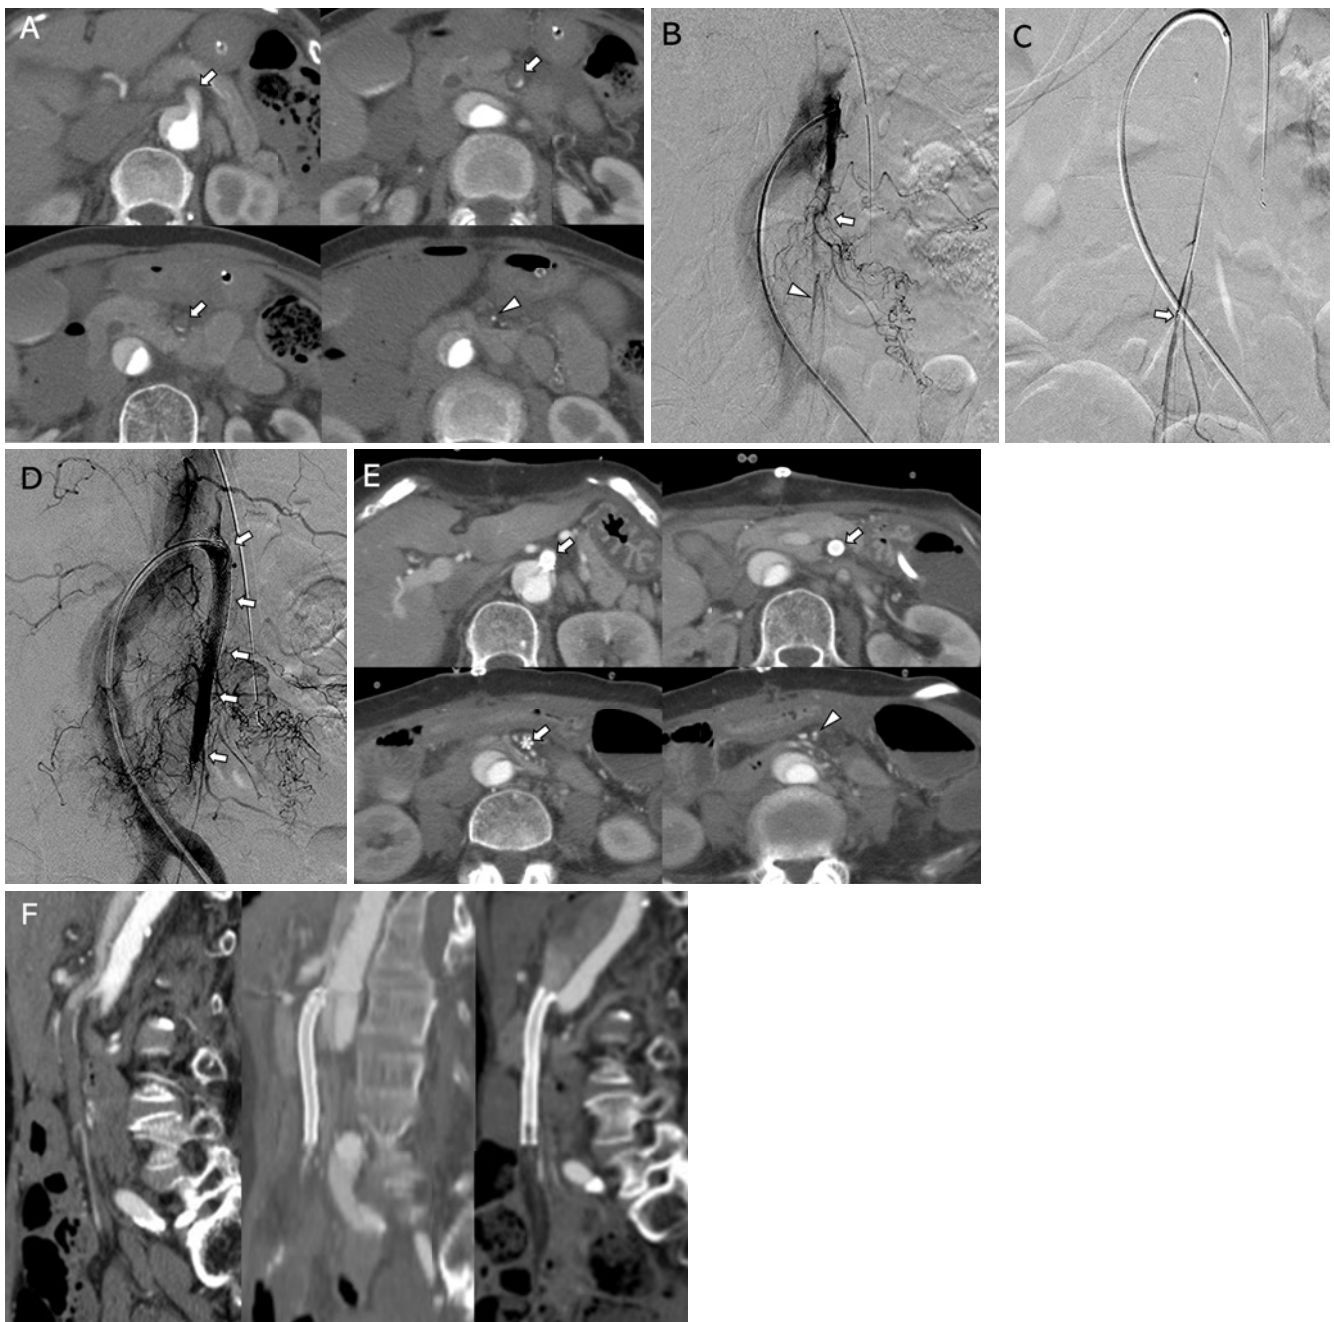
Images of a woman with Stanford type A aortic dissection complicating superior mesenteric artery (SMA) malperfusion (case 10). (A) Contrast-enhanced computed tomography (CECT) after ascending aortic replacement shows obstruction of the true lumen of the SMA by the thrombosed false lumen (arrow). The diameter of the SMA distal to the dissection (arrowhead) was 3.0 mm. (B) True lumen angiography of the SMA demonstrated obstruction of the SMA (arrow). The SMA distal to the ileocolic artery (arrowhead) was perfused by collaterals. (C) A 6 F guiding sheath (Ansel Guiding Sheath, Cook Medical, Bloomington, IN, US) was placed in the SMA orifice, and a 1.8 F microcatheter (Carnelian PIXIE, Tokai Medical Products, Aichi, Japan) was advanced distally to the dissected SMA through the true lumen. Next, angiography demonstrated the tip of the microcatheter (arrow) was in the true lumen of the SMA beyond the dissected lesion. (D) After exchanging a guidewire for a hard guidewire (Amplatz Super Stiff Guidewire, Boston Scientific, Marlborough, MA, US), a 7 mm diameter self-expanding stent (SMART Control, Cordis, Bridgewater, NJ, US) was placed in the SMA. Angiography after stent (arrow) placement showed improved flow of the side branches of the SMA; however, the SMA at the distal portion of the stent was poorly contrasted, and the in-stent flow was slow. Resection of the distal ileum and right hemicolon was performed immediately after stenting. (E) CECT 8 days after stenting showed that the stent (arrow) and SMA distal to the stent (arrowhead) were patent. (F) CECT curved planar reconstruction images before (left), 8 days (center), and 3 years (right) after stenting. CECT 3 years later shows that the proximal end of the stent is located in the false lumen of the aorta due to an intimal flap tear within the aorta by the proximal edge of the stent. The distal edge of the stent was occluded at 3 years; however, the patient remained asymptomatic, and CECT showed no intestinal ischemia.
